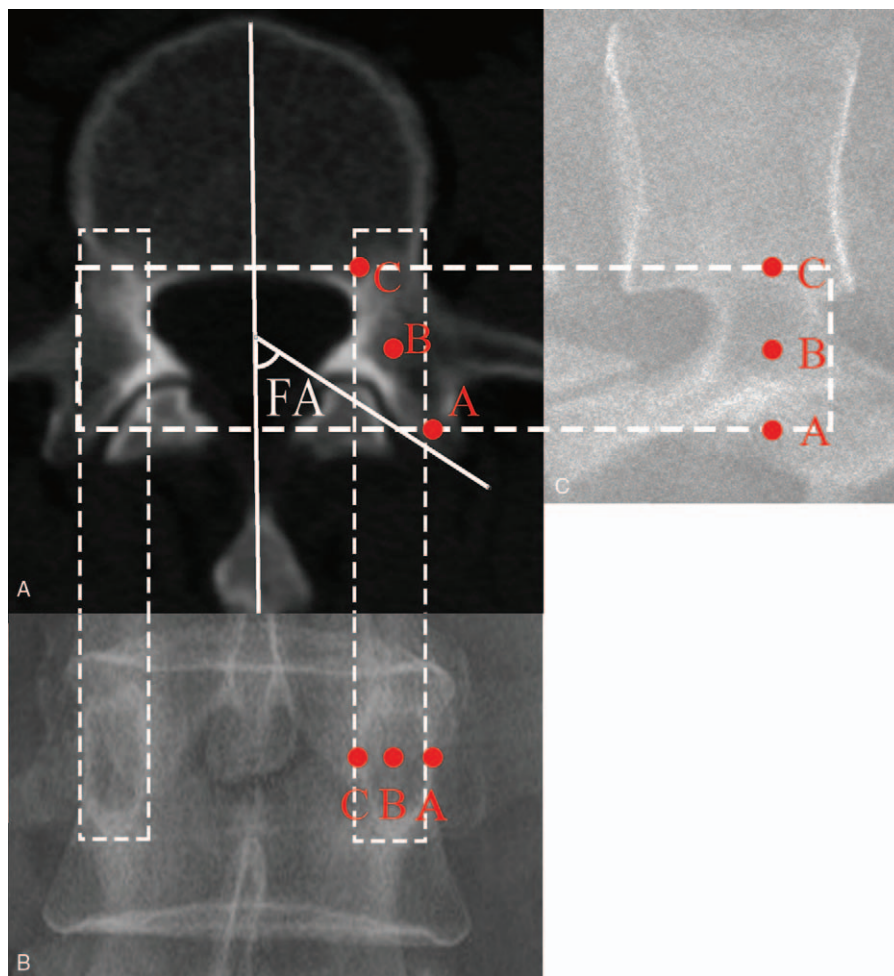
(A) FA measurement: select transverse section image of the pedicle on the lumbar CT, measuring the angle between the facet joint and vertebral axis (angle between the solid white line). (B) Dashed line shows the oval-shaped pedicle ring of the pedicle on CT and the projection on the anteroposterior-lateral C-arm fluoroscopy, indicating overlapping of the facet joint and oval-shaped pedicle ring, and the larger FA occupying a larger screw pathway. The red A, B, and C dots indicate the relationship between the 3 checkpoints of the anteroposterior-lateral C-arm fluoroscopy with those of the CT image. CT = computed tomography, FA = facet angle.
